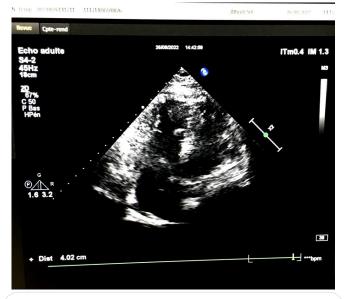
Echocardiography, apical incidence, right ventricle is non-dilated and slightly hypertrophied.
